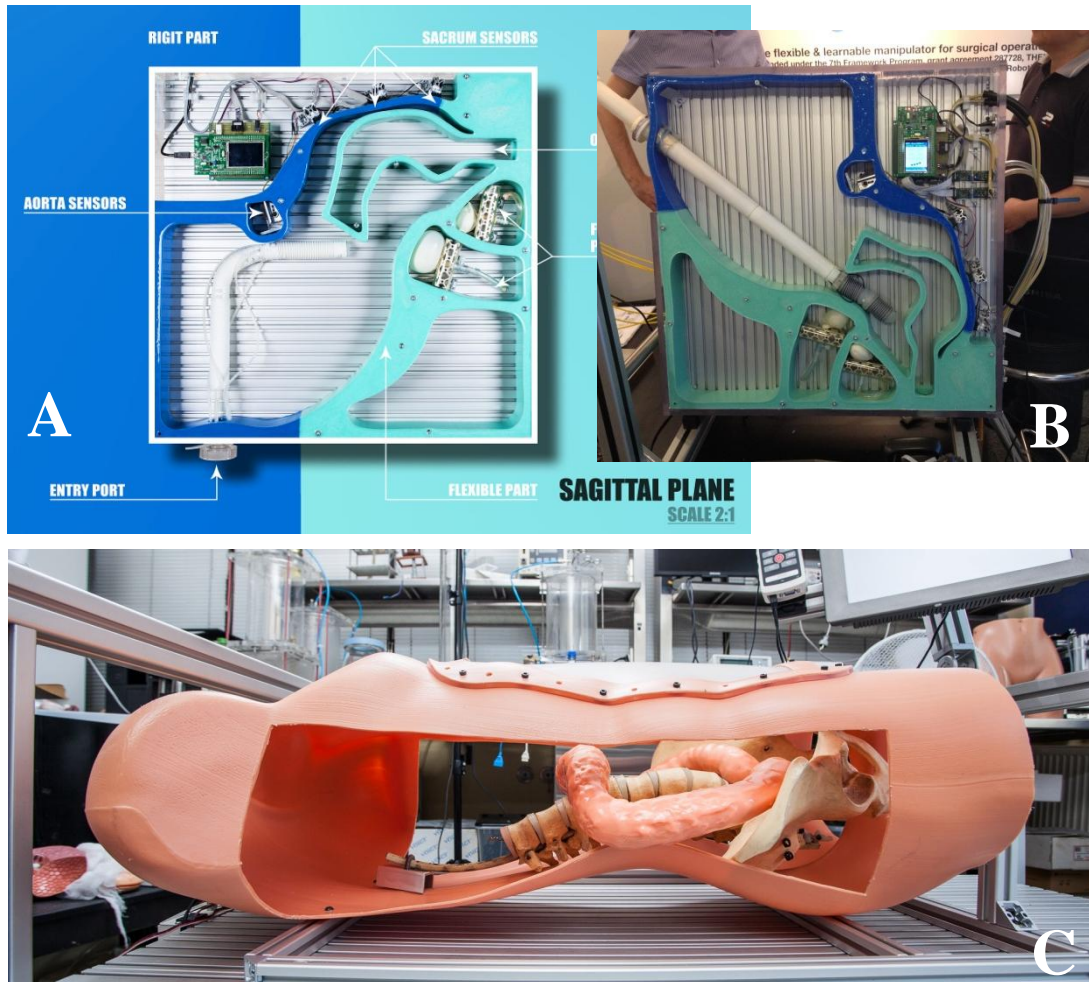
2:1 scale human abdomen models. A: project of a 2D model with sensors embedded for preliminary tests. B: Setting of the manufactured model for tests. C: 3D human abdomen model with realistic representation of bones and viscera derived from a CT reconstruction
